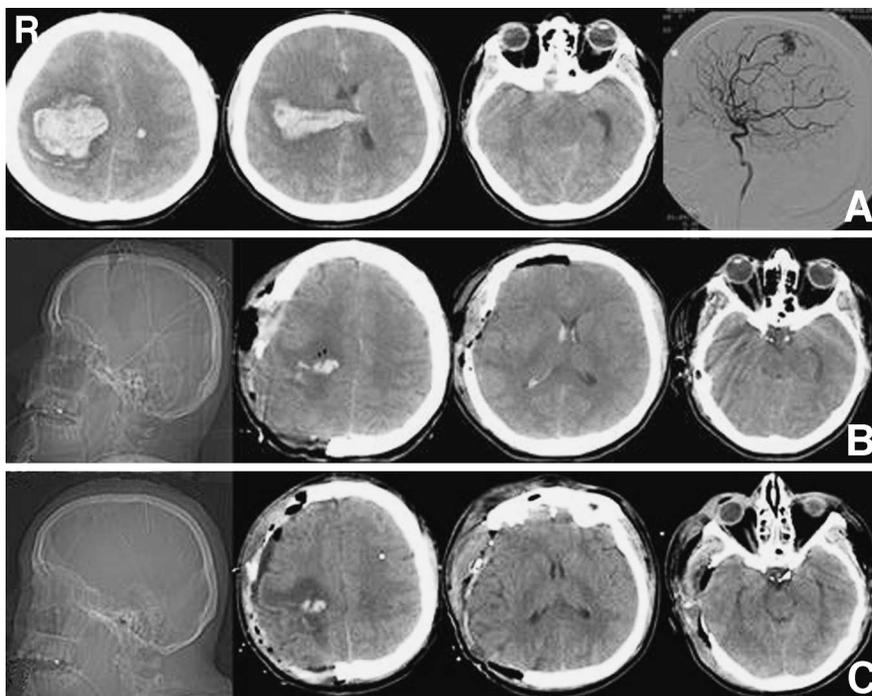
Case 2. A: Axial computed tomography (CT) scans on admission and subsequent right carotid angiogram disclosing a large right fronto-parietal hematoma related to a fronto-parietal arteriovenous malformation. B: Postoperative CT scout view and axial CT scans showing a fronto-parietal craniectomy, intracerebral hematoma evacuation, and immediate midline realignment, but the persistence of perimesencephalic cistern effacement. C: CT scout view and axial CT scans after craniectomy demonstrating better visualization of the perimesencephalic cisterns.
